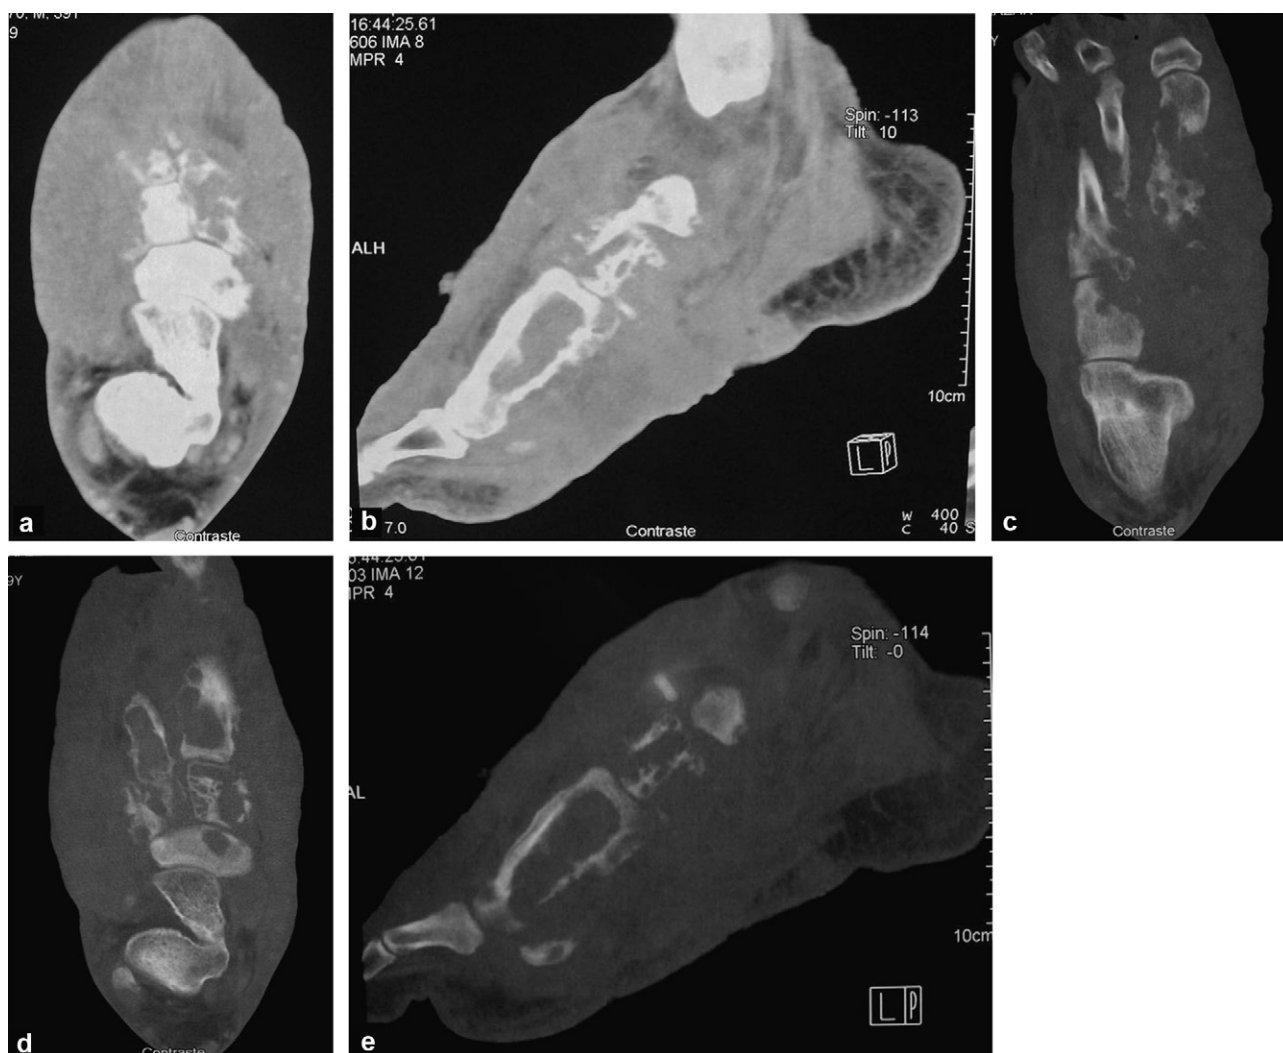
Volume computed tomography (CT) of the foot after injection of contrast product. a and b: soft tissue window: frontal (a) and sagittal (b) slices: diffuse infiltration of the dorso-plantar soft tissue, enhanced heterogeneously with hyperdense micronodules; c, d and e: bone window: frontal and sagittal slices: diffuse osteolysis of the cuneiform, metatarsal and sesamoid bones with geodes of the navicular and cuboid bones and an irregular periosteal reaction.
